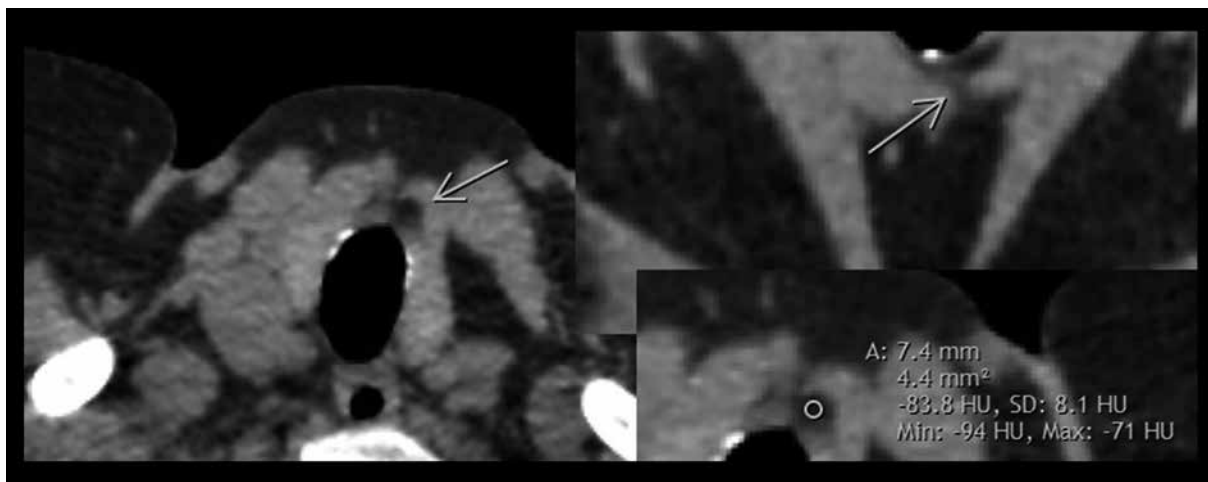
Thyrolipoma on computed tomography of the chest in a 61-year-old woman undergoing imaging because of chronic cough and suspected chronic obstructive pulmonary disease. The found thyrolipoma is connected to the surrounding fat tissue via a fatty band, a finding named the “scoop sign”. Density measurements showed fat isodensity (-83.8 HU).
